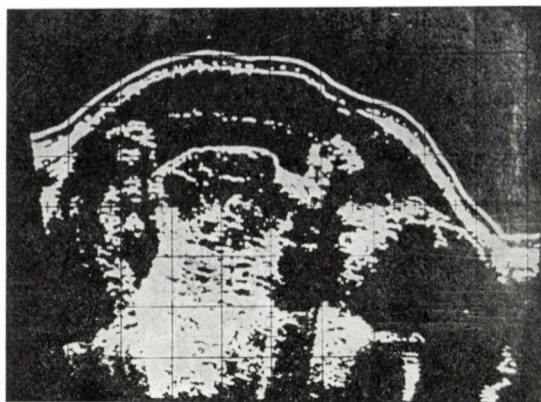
Ultrasound scan showing the thick limbs and the large head
